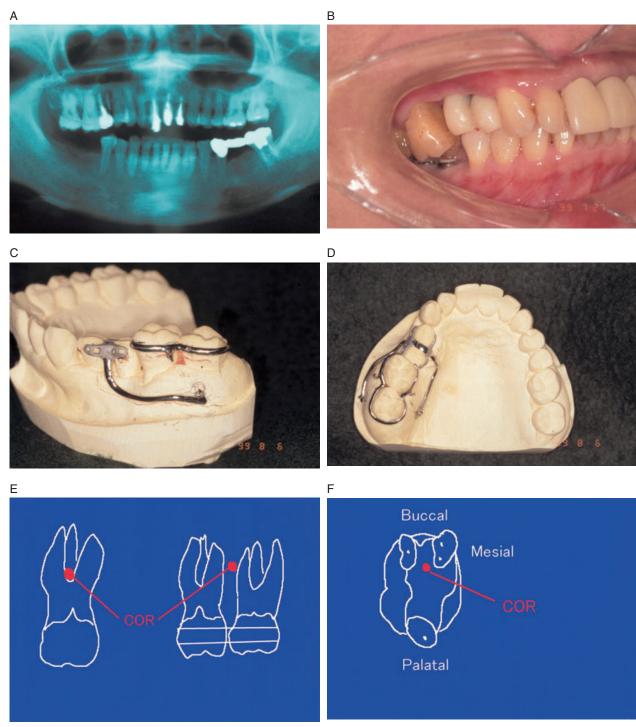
A*, Panoramic X-ray taken at the initial visit. *B*, Supra-erupted teeth 16 and 17 before intrusion. *C*, Buccal surface view of the orthodontic appliance. *D*, Occlusal surface view of the orthodontic appliance. *E*, Position of the center of resistance (COR) for individual teeth and combined teeth. *F*, The COR of maxillary molars is slightly to the buccal side.
